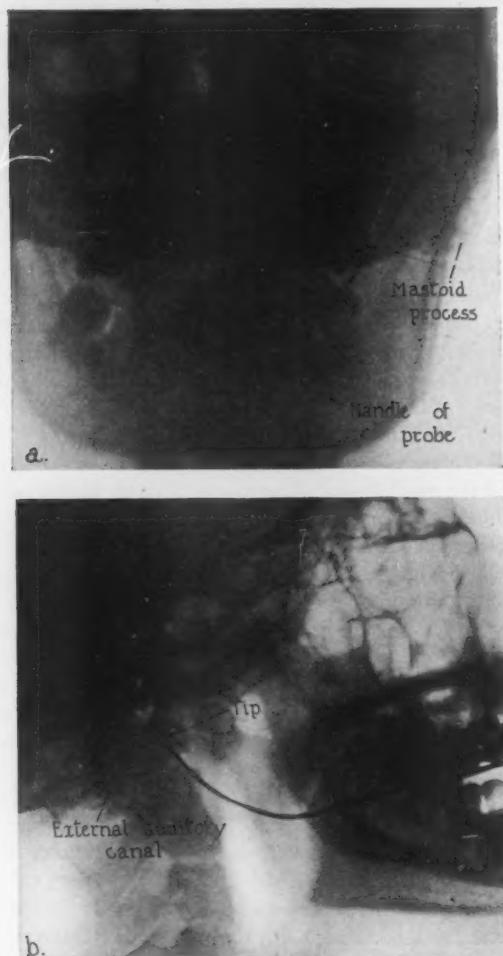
Roentgenograms showing location of probe in sinus tract.
